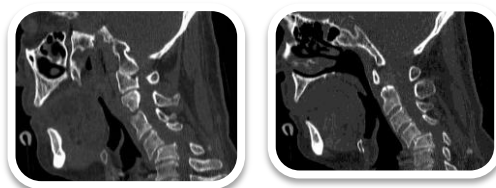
Cervical computed tomography (CT) scan, anterior subluxation of C4 vertebra on C5 with severe narrowing of spinal canal
